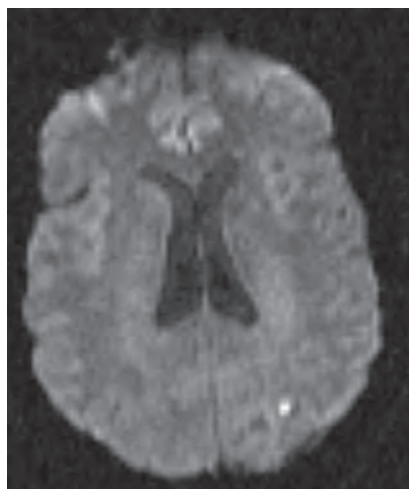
DWI image showing acutely restricted diffusion in left parietal lobe in a 45-year-old patient who presented with a TIA.
